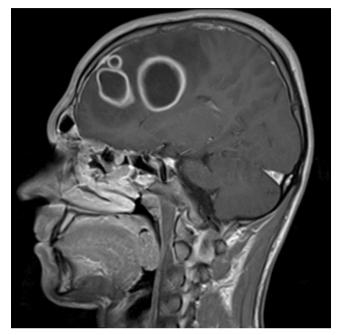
MRI of the head. Patient KZ, age: 20. Patient's chart no. 25260/2013. Three abscesses in the right frontal lobe, 38, 25 and 10 mm in diameter, respectively.
